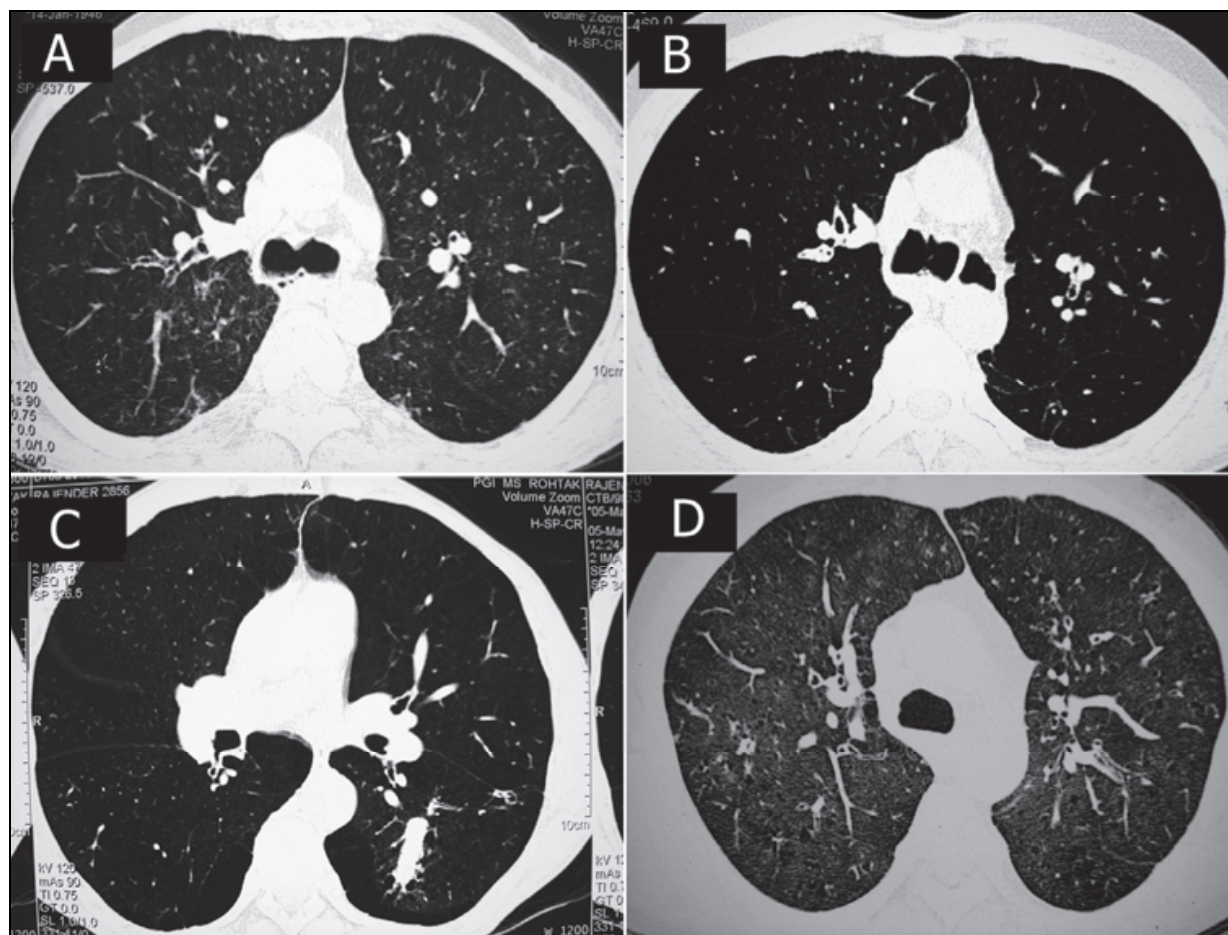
(A-D): HRCT scans from COPD showing increased sterno-aortic distance and the anterior junctional line.
